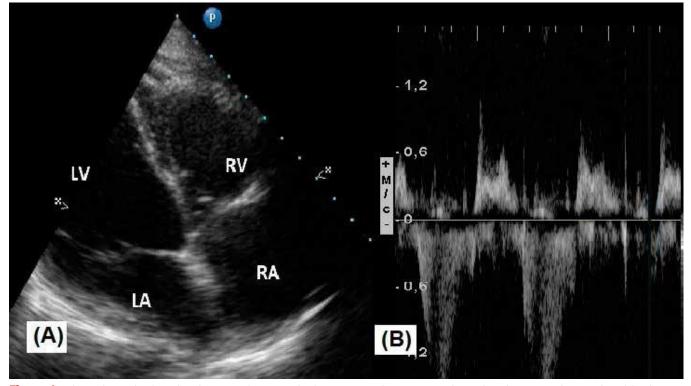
Echocardiographic four-chamber view after 3 month of treatment with corticosteroid. Panel A. Almost complete resolve of the thrombotic mass within the RV cavity. Panel B. Doppler-echocardiography shows the improvement of the right ventricular filling
